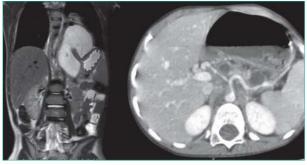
Magnetic resonance imaging showing the intrathoracic extension and gastric artery at the base of pseudocyst
